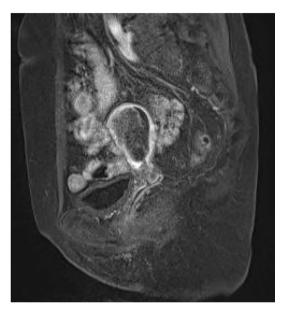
Saggital T1-weighted contrast-enhanced magnetic resonance imaging (after gadolinium administration) showing endometrial tumor with deep myometrial invasion.
